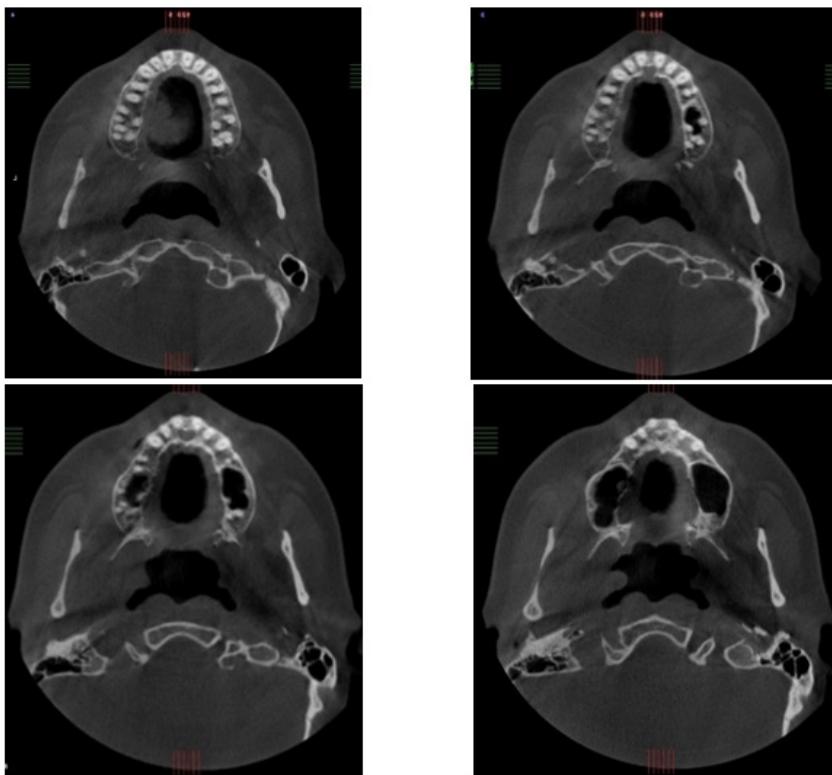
Axial CBCT images show a heart-shaped nasopalatine duct cyst.
